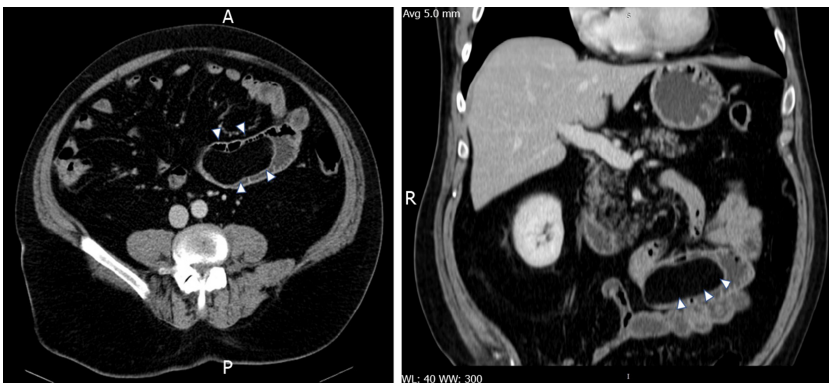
Contrast-enhanced abdominal computed tomography scan. Both axial (left) and coronal (right) reformatted images show a large elongated structure inside of intestinal lumen (arrowheads) with homogeneous fat density and smooth, well defined contour.
